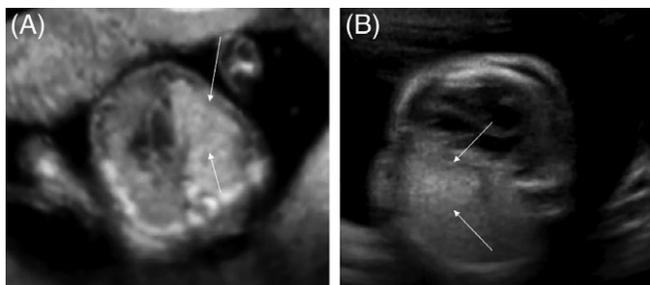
A and B, Sonograms of the chest showing an echogenic lung mass (arrows) and displacement of the heart to the right
